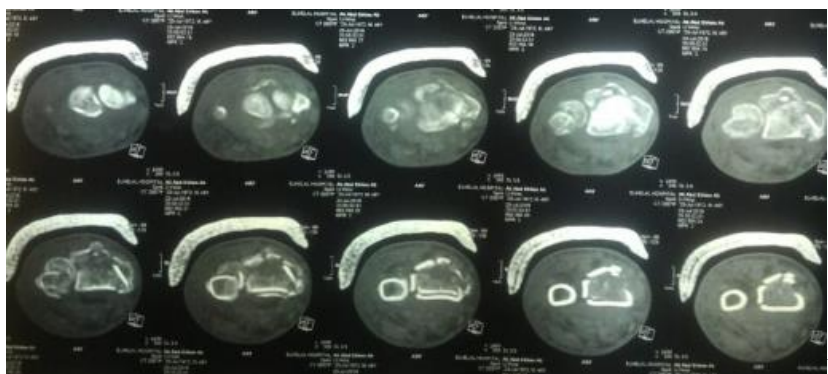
A: preoperative x-ray & CT, B: Immediate postoperative
